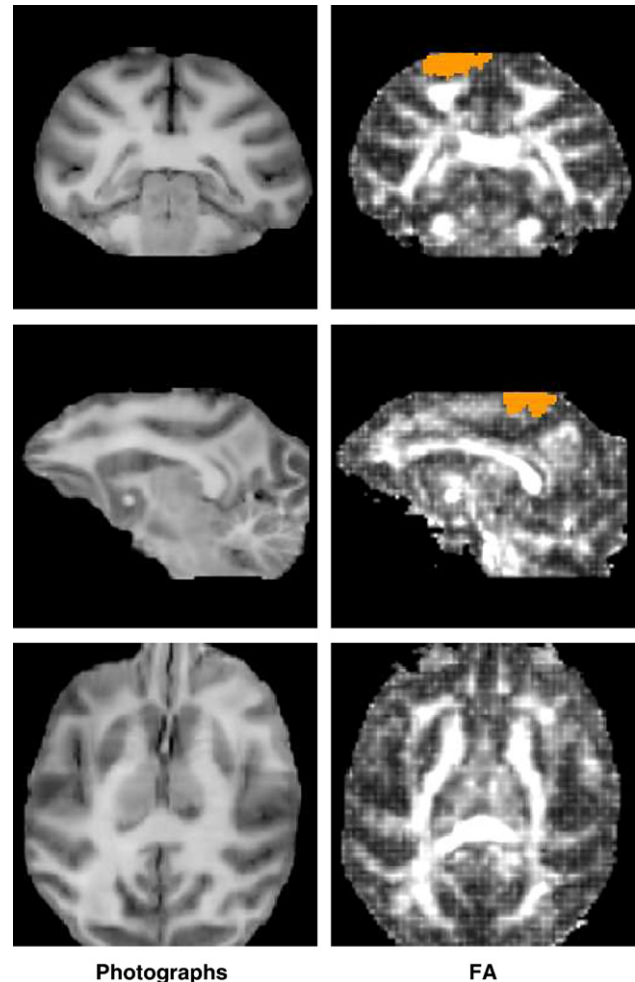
Photographic volume in the in-vivo MRI geometry after 3D reconstruction and elastic correction (left) compared to fractional anisotropy (FA) image estimated from the DTI data (right). The segmented injection sites used as seed regions are shown in orange. From top to bottom: coronal, sagittal and axial views.
